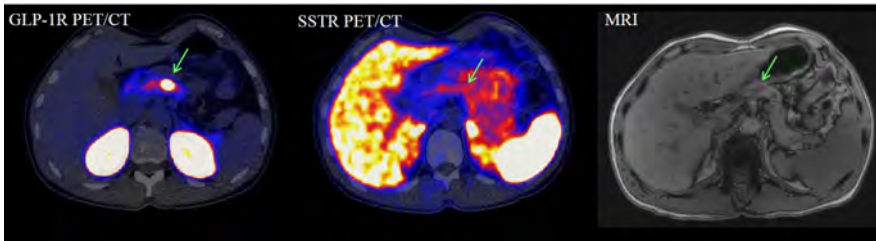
Images of GLP-1R PET/CT, SSTR PET/CT and MRI (T1) of patient 8. Location of the tumor is indicated with green arrows.
